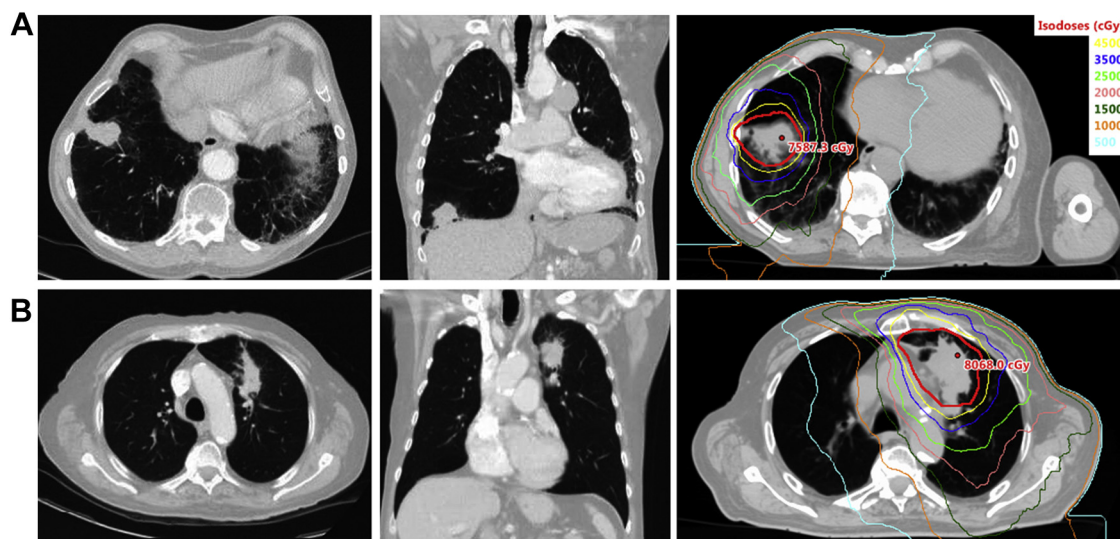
Diagnostic and treatment planning computed tomography scans of two patients. (A) A patient with a nonclassifiable fibrosis who died of cardiac failure and possible radiation pneumonitis 12 months after stereotactic ablative radiotherapy. (B) A patient with mild emphysema who died of an unknown cause 30 months after stereotactic ablative radiotherapy. The planning target volumes are shown in red.
